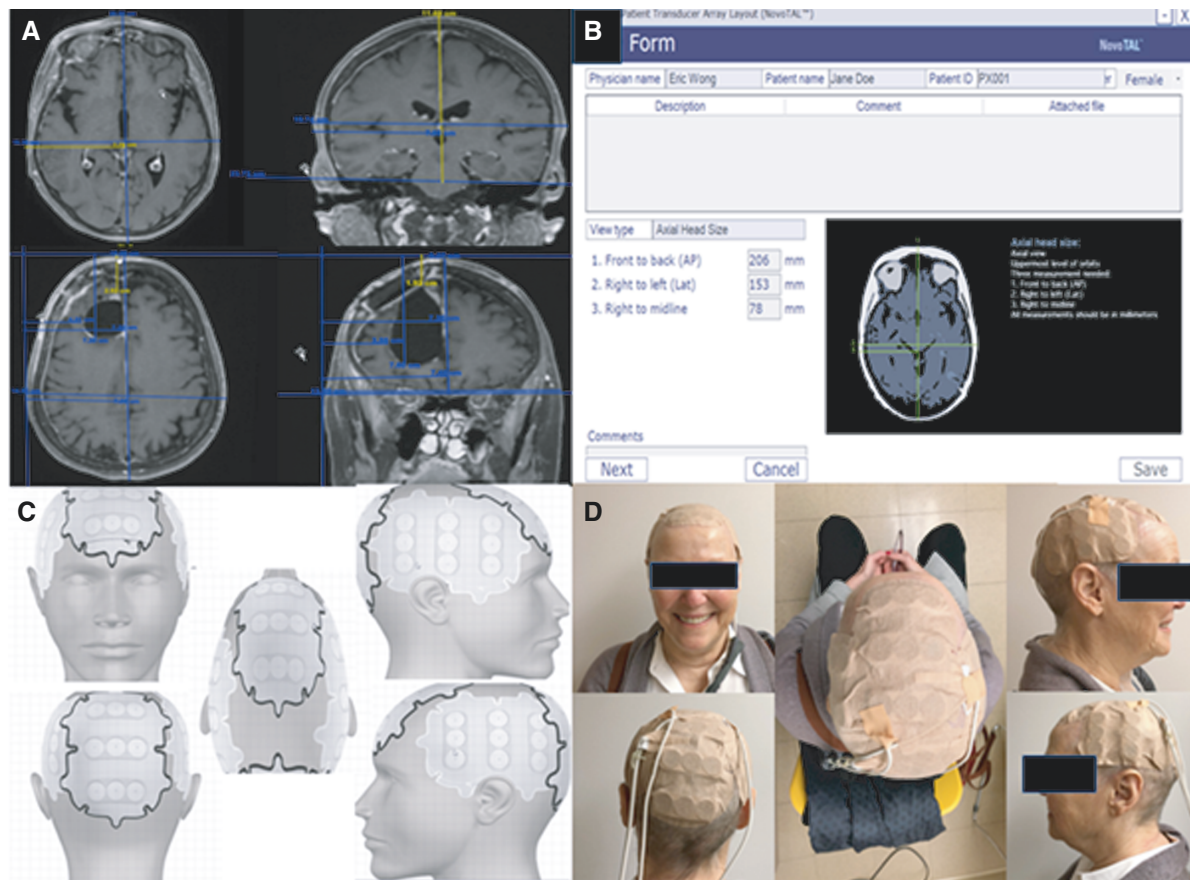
NovoTAL array mapping for the Tumor-Treating Fields device Optune. (A) The patient's head size was measured on MRI DICOM images in the anterior-posterior and right-left directions in the axial view, and in the rostral-caudal and right-left directions in the coronal view (upper panels). The residual tumor adjacent to the resection cavity was also measured in the axial and coronal views (lower panels). (B) The measurements were then entered into the NovoTAL software. (C) The array map was generated by the software in the anterior, right, left, and posterior positions (clockwise), as well as the top view showing all 4 arrays (center). (D) The transducer arrays were then applied to the patient as seen in the anterior, right, left, and posterior positions (clockwise), and in the top view showing all 4 arrays (center).
